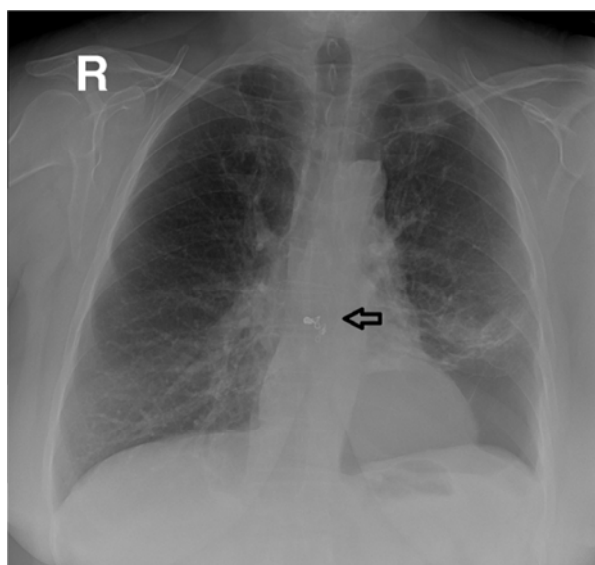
Antero-posterior view chest x-ray following coil embolization and demonstration the left lower lobe bulla prior to surgical resection.
